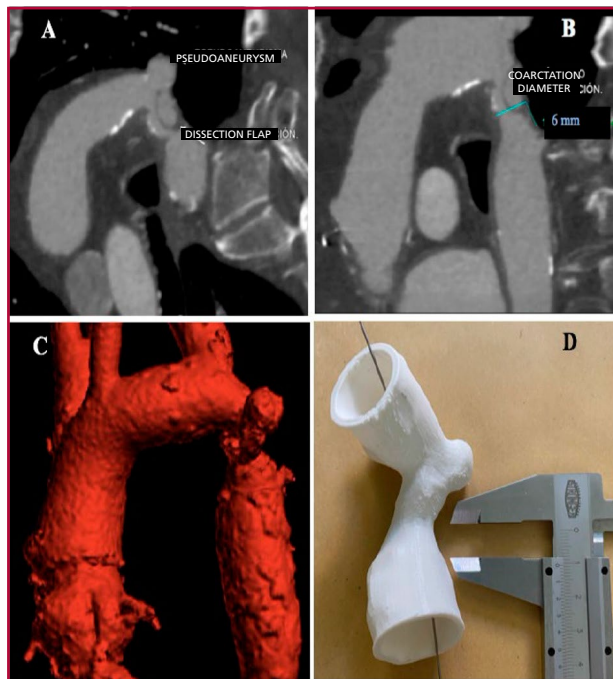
A-B: Sagittal section of CT angiography showing pseudoaneurysm, dissection flap and diameter of aortic coarctation. C-D: 3D reconstruction of aortic coarctation associated with pseudoaneurysm.
